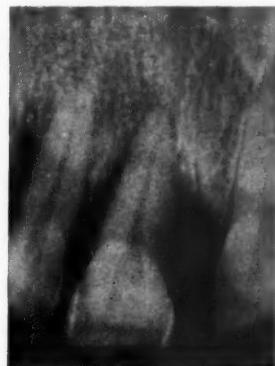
Maxillary right lateral incisor with extensive bone destruction associated with the pointing of a periapical abscess not readily apparent radiographically but demonstrating need for vitality tests.
